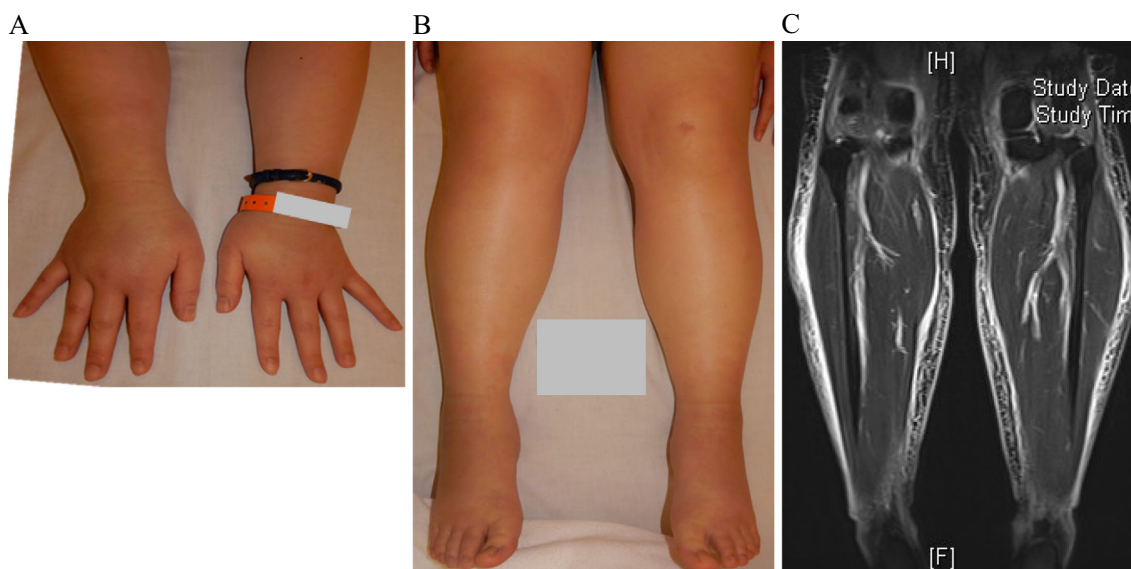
Clinical image of the patient with angioedema with eosinophilia. (A, B) Symmetrical edema of her hands and legs. (C) MRI revealed prominent subcutaneous edema (short T inversion recovery).
